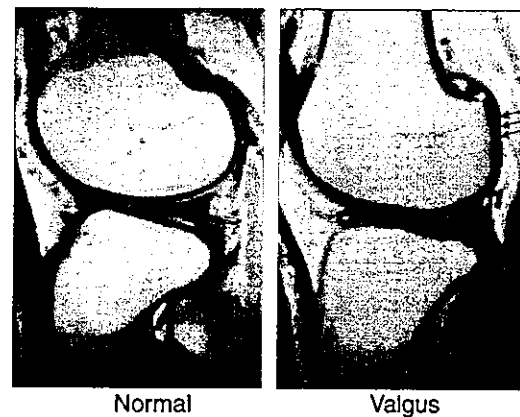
Magnetic resonance image shows a sagittal view of the distal femur in a normal knee (Left). Magnetic resonance image shows a sagittal view of the distal femur in a valgus knee (Right). The posterior part of the lateral condyle is flat in shape.
